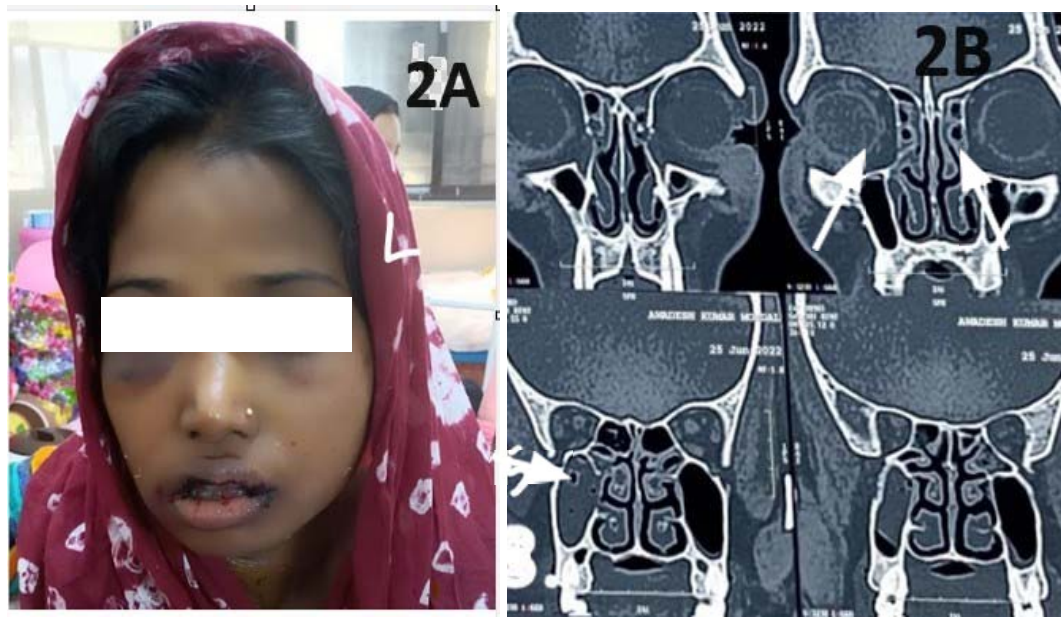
(a-b): (a) Raccoon eye at presentation and (b) CT PNS showing bilateral hypodense mucosal thickening and HALO sign suggestive of fungal sinusitis
